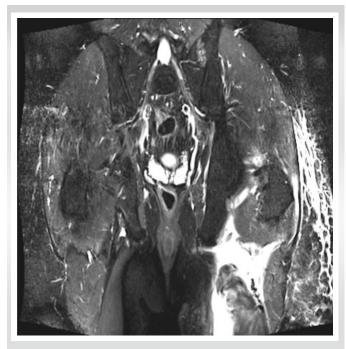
Coronal short tau inversion recovery (STIR) MRI of the left hip showing the complete proximal hamstring tendon rupture with 8 cm oftendon retraction and large surrounding hematoma.
